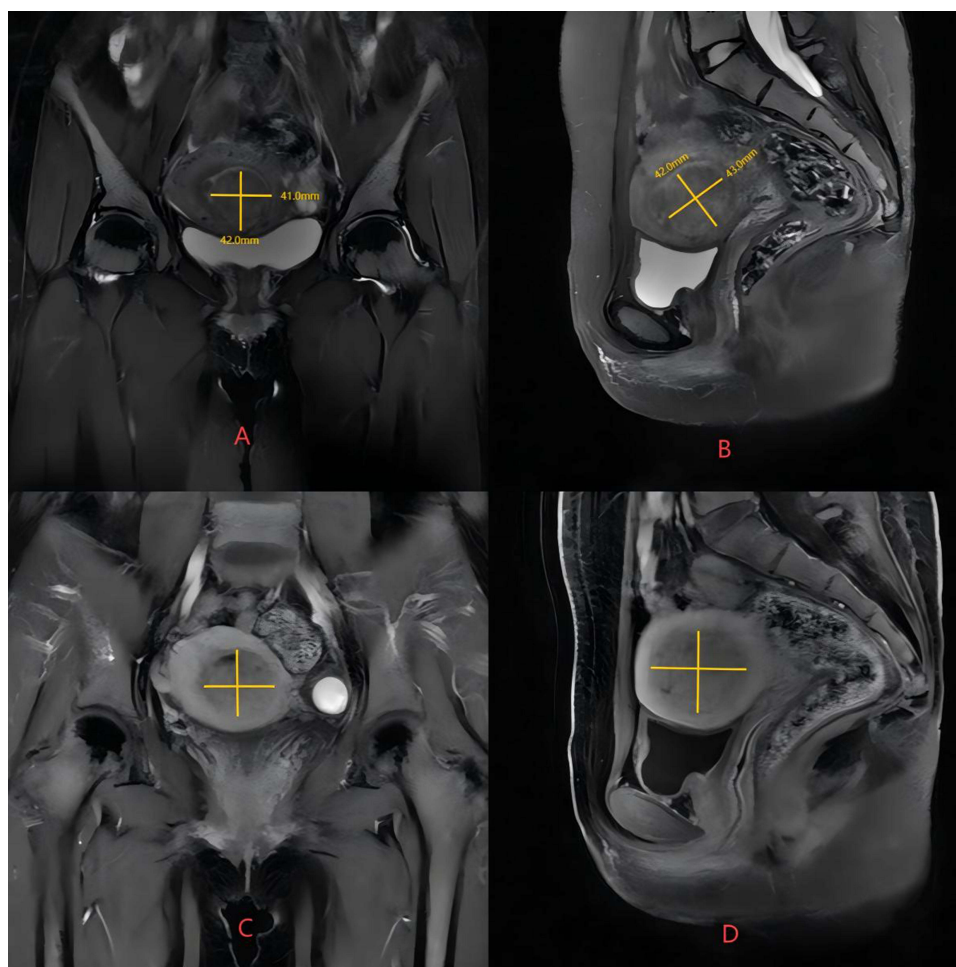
Magnetic resonance imaging of the largest myoma in the uterine cavity before HIFU treatment (A and B). Magnetic resonance imaging of the largest myoma in the uterine cavity after contrast enhancement (C and D).
